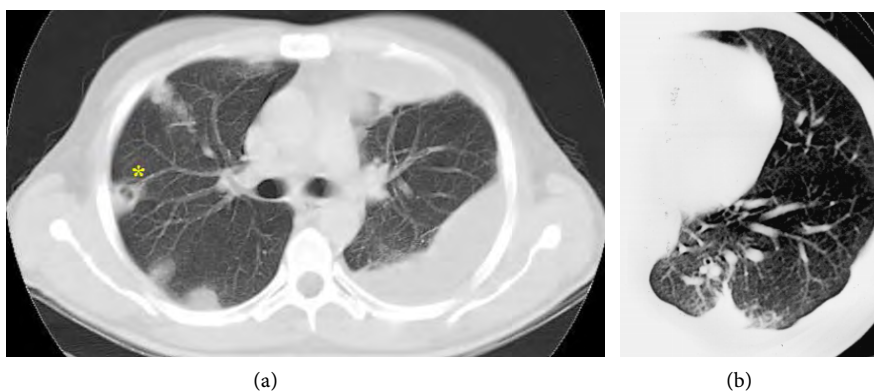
CT findings seen in SPE. (a) Multiple peripheral nodules, and a feeding vessel sign (Asterix); (b) Wedge shaped peripheral lesion abutting the pleura [7].
